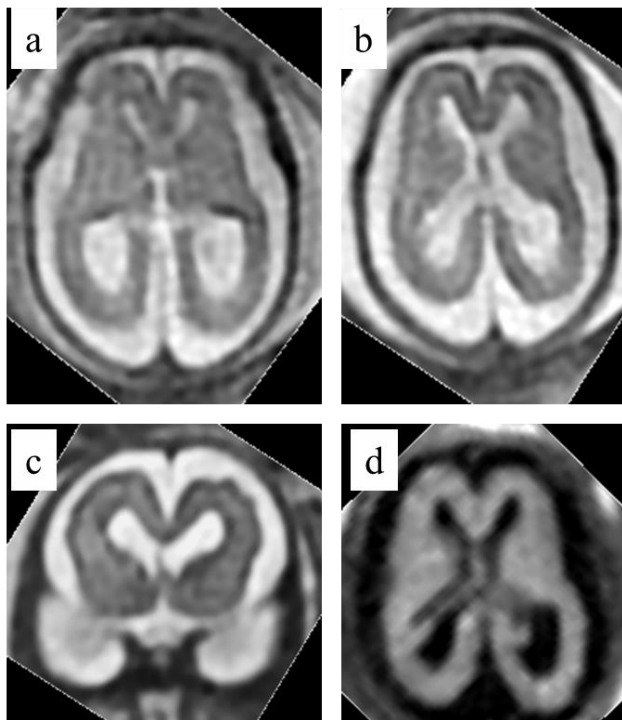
A fetus with confirmed transplacental infection with cytomegalovirus. Axial (7a and 7b) and coronal (7c) T2-weighted images of a 23gw fetus with mild ventriculomegaly on ultrasound. Fetal ascites had been recognised at 20gw. Mild ventriculomegaly is confirmed on iuMR but there is also micro-encephaly, poor visualisation of the sylvian fissures and uneven cortical plates in the frontal regions. Patchy abnormal signal intensity is present on axial diffusion weighted imaging (7d).
